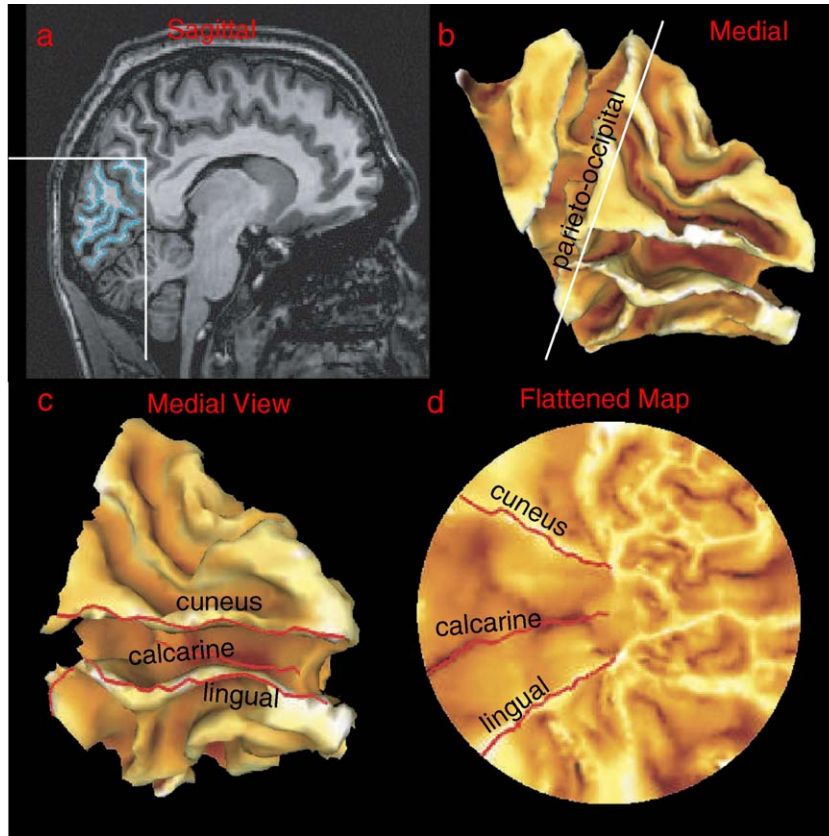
Anatomical MRI analysis. (a) Sagittal slice in the MRI volume. The white lines delineate the region of interest, and the blue contour indicates the location of the GM/WM interface. (b) Right occipital lobe. The cut is delimited by the white line parallel to the parieto-occipital sulcus. (c–d) Right occipital surface and its planar map. Bright color denotes gyrus regions with positive curvature, while dark color indicates sulcus regions with negative curvature. Calcarine sulcus, cuneus, and lingual gyri (red lines) are defined by principal curve tracking (Ratnanather et al., 2003).
